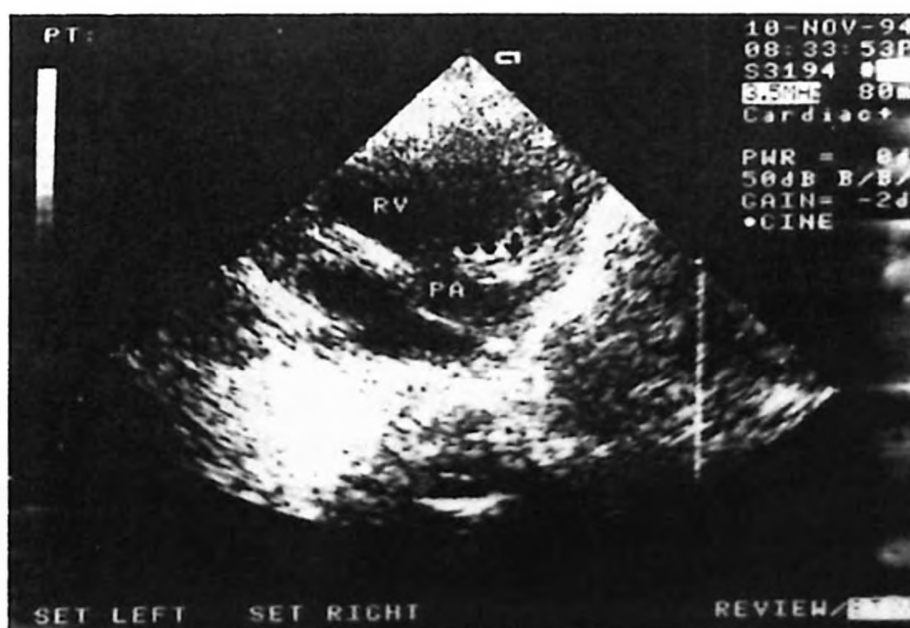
Two-dimensional echocardiogram in the parasternal short-axis view (Case 3) showing the LCA (arrows) originating from the pulmonary artery.
